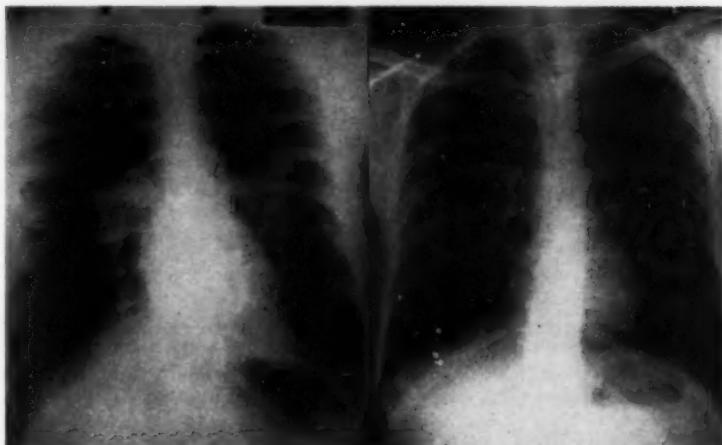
Chest roentgenogram demonstrating simultaneous bilateral pneumothorax (see text). FIGURE 2: Chest roentgenogram of same patient taken six weeks postoperatively.
